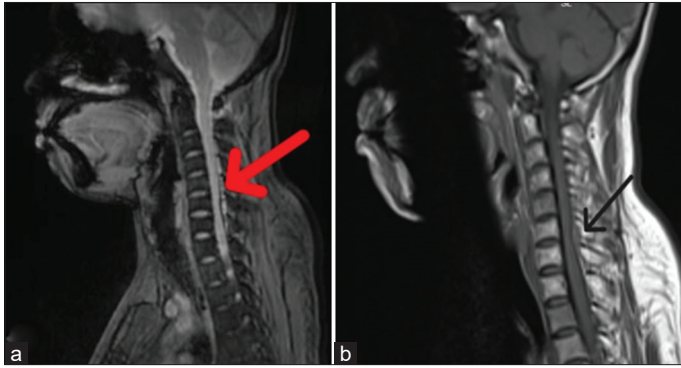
(a and b) Magnetic resonance imaging showing T2 hyperintense lesion in C6-T2 region suggestive of epidural hematoma; T1 weighted image
